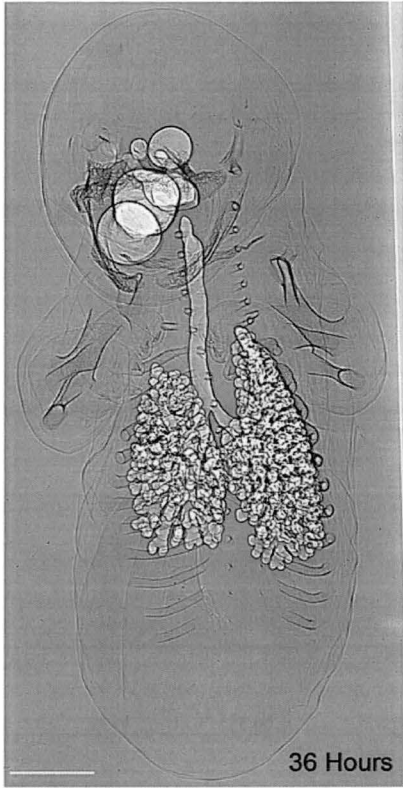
Phase contrast X-ray imaging of the developing fat-tailed dunnart.
